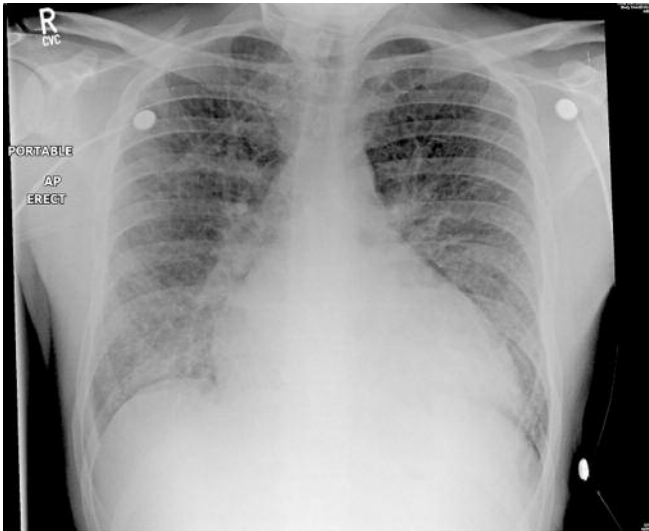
AP chest radiograph on admission to hospital
